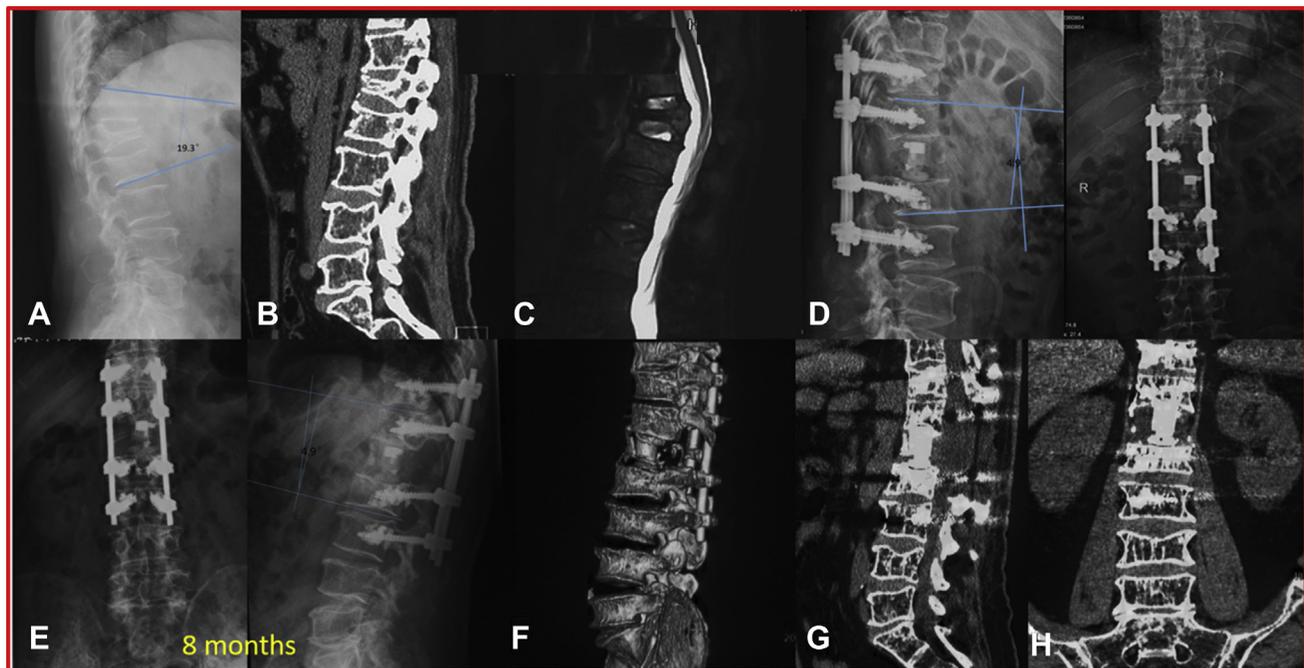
Imaging studies of a 61-year-old man with a diagnosis of prostate cancer metastasis. Preoperative thoracolumbar (A) radiographic, (B) computed tomography (CT), and (C) magnetic resonance imaging studies demonstrating tumor-induced destruction of the L1 vertebral body and kyphosis (Cobb angle, 19.3°). The patient underwent L1 spondylectomy and fusion with the height-adjustable vertebral body (AHVB). (D) The kyphosis was corrected, with Cobb angle improvement from 19.3° to 4.9° .
